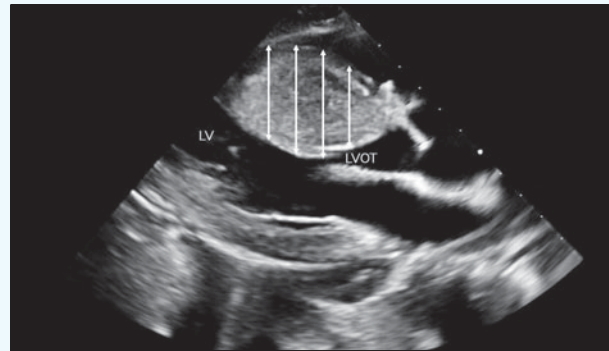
The patient's echocardiogram showing septal hypertrophy (white arrows); LV, left ventricle; LVOT, left ventricular outflow tract.
